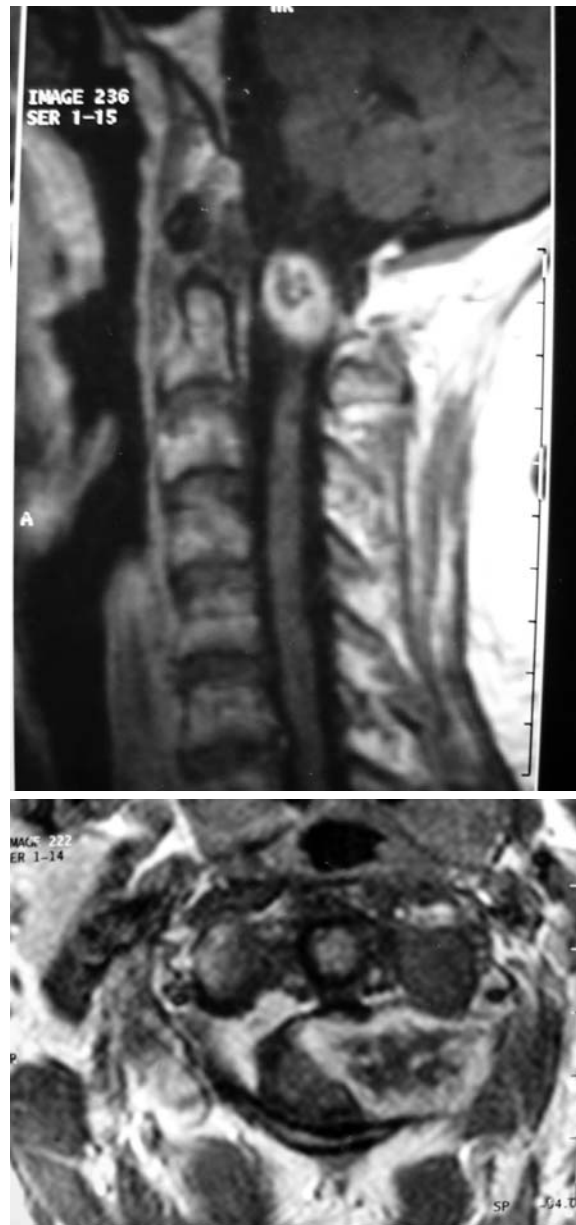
(A) A hyperintense mass overlying the left transverse process was observed on preoperative, sagittal, contrast-enhanced, T1-weighted magnetic resonance images of the spine. (B) On axial, contrast-enhanced T1-weighted magnetic resonance images of the patient performed preoperatively, a hyperintense mass, with intra and-extradural components, extending toward the left transverse process was observed.
